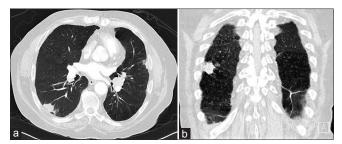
Selected axial (a) and coronal (b) computed tomography images from a CT chest performed 14 months after the initial myocardial perfusion scintigraphy occurred. A 23 mm opacity was now present within the right lower lobe with associated hilar lymphadenopathy and multiple smaller opacities within the lung fields. Subsequent computed tomography-guided biopsy revealed lung squamous cell carcinoma
